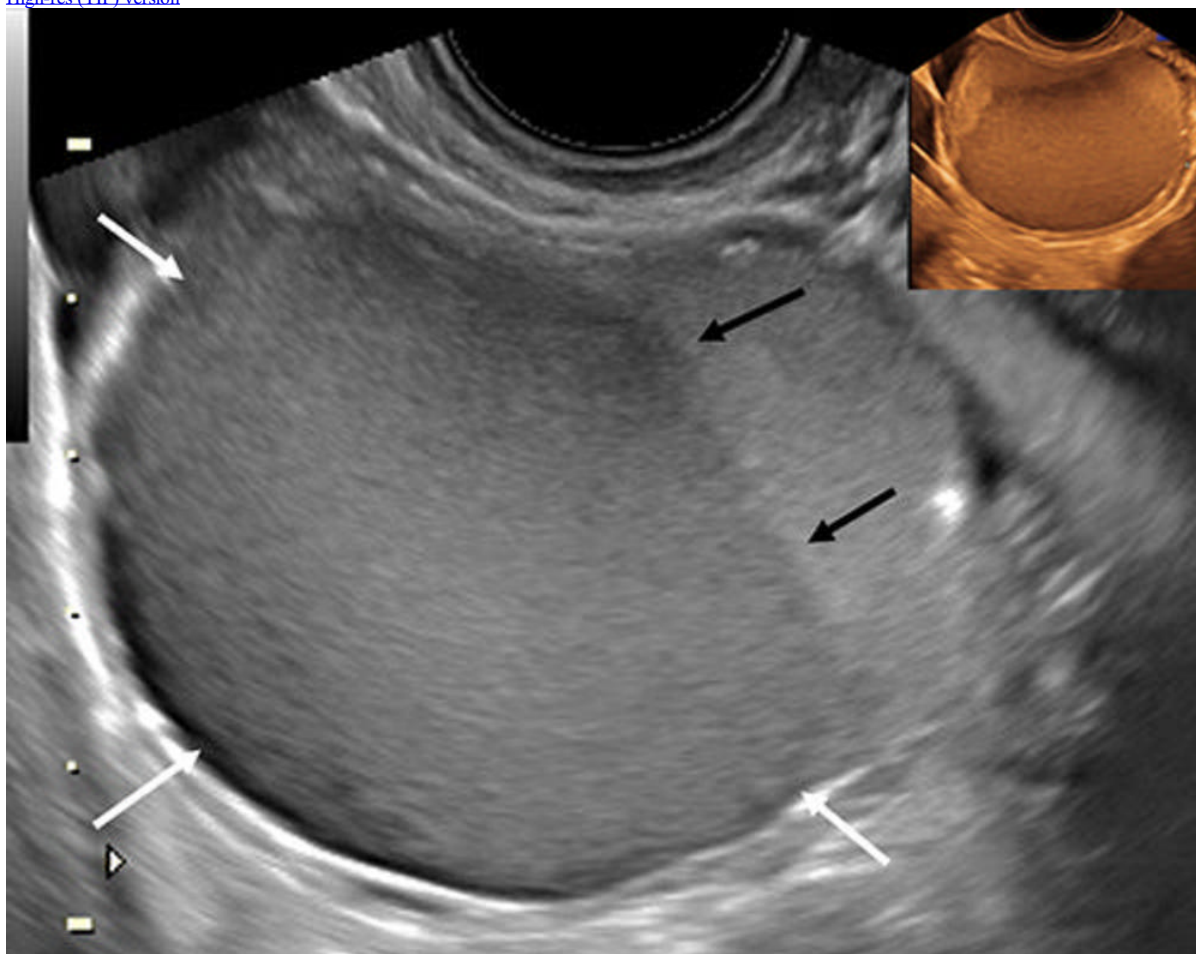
Transvaginal longitudinal US scan in a 31-year-old patient with deep dyspareunia shows an endometrioma with homogeneous low-level (ground glass) echoes (white arrows) and fluid-fluid level (black arrows). Sepia inset in transverse view shows similar observations, a category A (direct endometriosis) observation. Adapted, with permission, from Young SW, Groszmann Y, Dahiya N, et al. "Sonographer-acquired ultrasound protocol for deep endometriosis" *Abdominal Radiology*.
